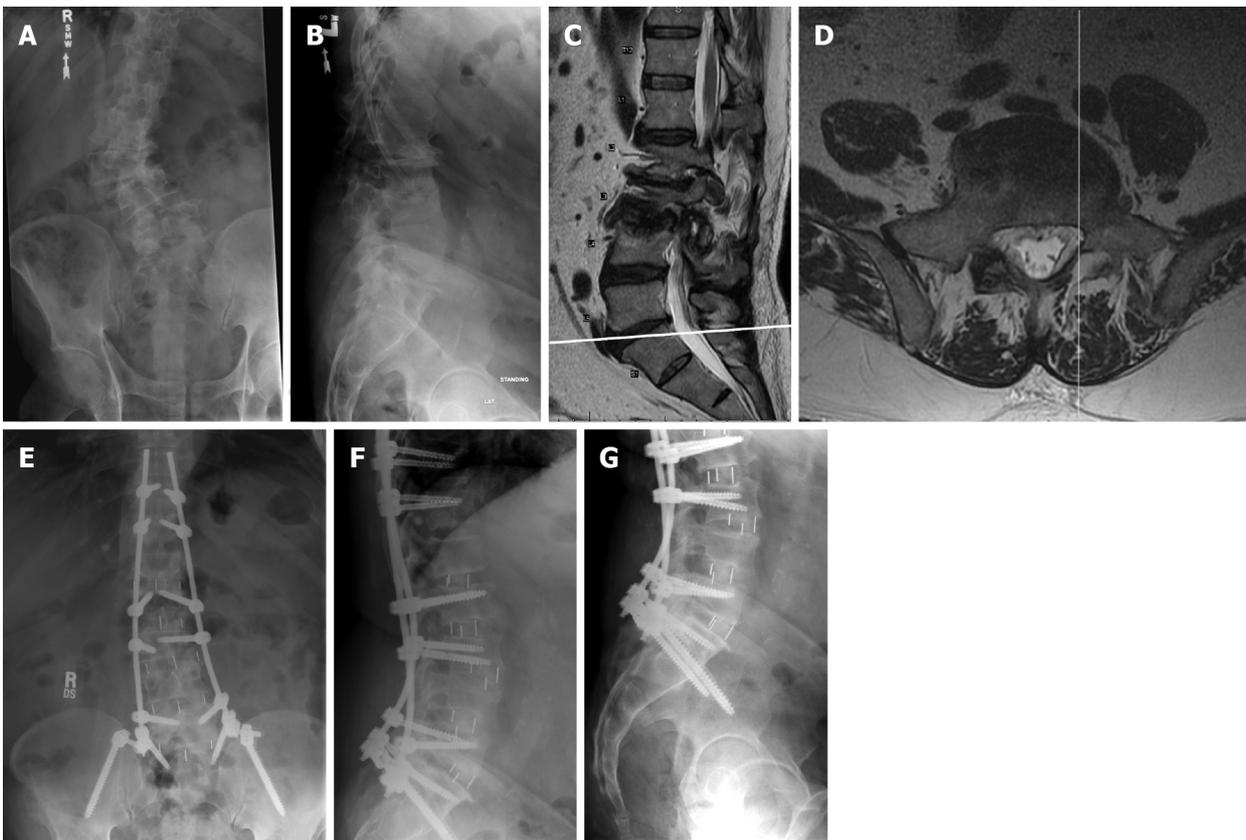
Preoperative upright anteroposterior (A) and lateral (B) radiographs, preoperative magnetic resonance imaging sagittal (C) and axial (D) images, and postoperative anteroposterior (E) and lateral (F, G) upright radiographs for Case 2. Image C shows the scout line corresponding to the axial image D. The left common iliac vein is in the midline medial to the anteroposterior *facet line* (D). CIV: Common iliac vein.
